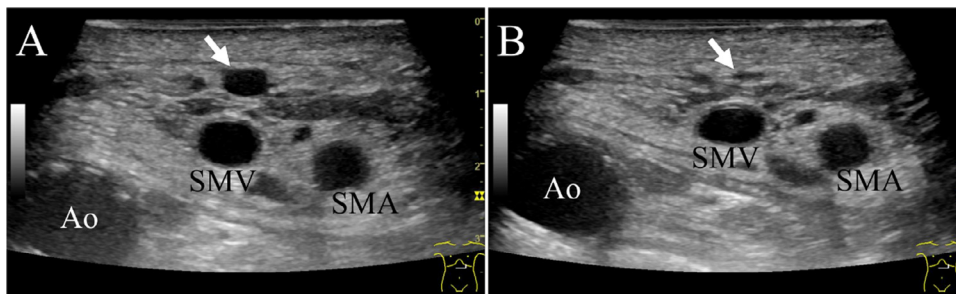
Abdominal ultrasound image of the middle colic vein. (A) Ultrasound reveals that the middle colic vein (arrow) is dilated and runs just below the peritoneum. (B) With the application of gentle compression using the ultrasound probe, the middle colic vein (arrow) is flattened. Ao; aorta, SMA; superior mesenteric artery, SMV; superior mesenteric vein
